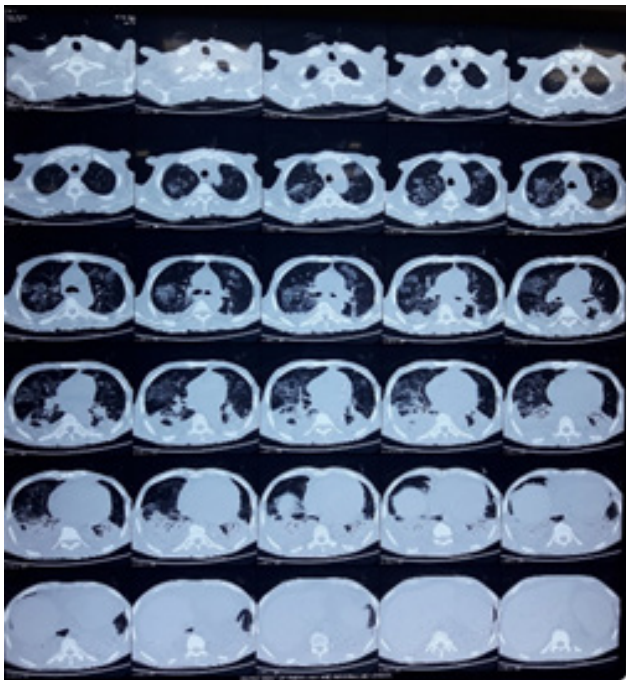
CT scan of chest
